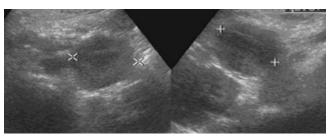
Ultrasound grayscale image showing a well defined hypoechoeic mass in the left renal hilum measuring ~2 x 2 cm.
